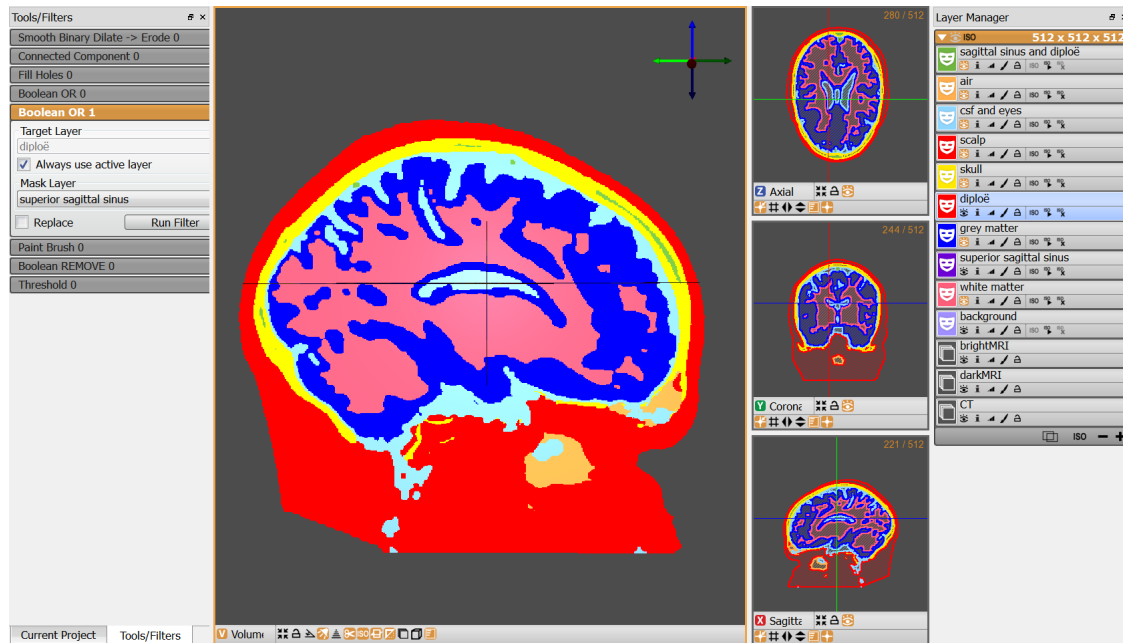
The Seg3D workspace after completed CT&MRI segmentation - Screenshot of the Seg3D workspace after completed segmentation of the CT and MRI scan. To the right are the created tissue layers and to the left the tools used.
